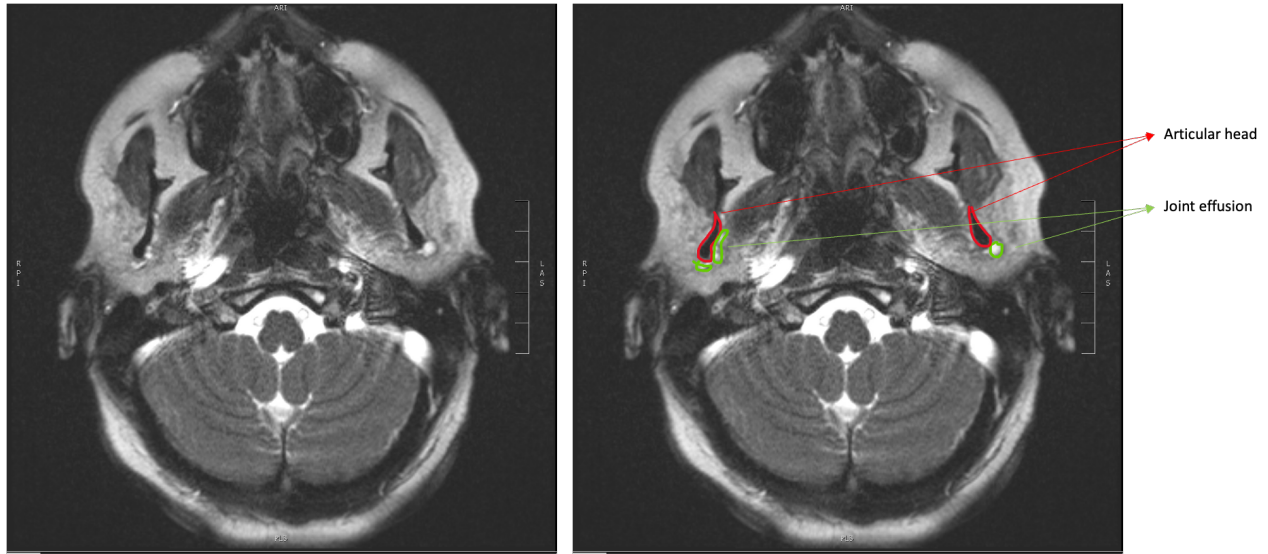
T2-weighted MRI coronal view. T2-weighted MRI coronal view demonstrating bilateral joint effusions.
